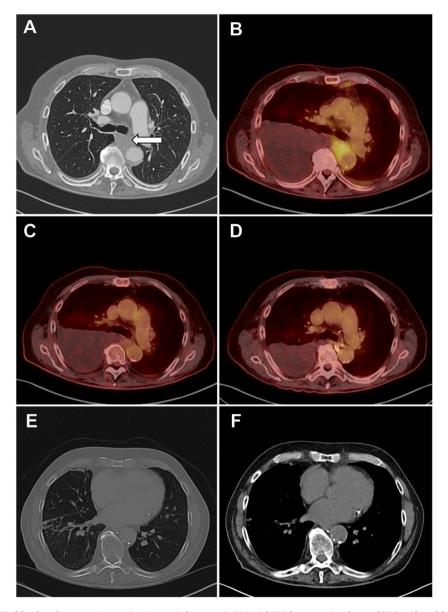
(A) Contrasted CT of the chest demonstrating a periaortic mass (white arrow). (B) Initial PET demonstrating abnormal FDG-avidity of the soft mass encasing the descending thoracic aorta. (C) PET mid-chemoimmunotherapy demonstrating interval decrease in size and FDG uptake of the soft tissue in the posterior mediastinum. (D) PET post-chemoimmunotherapy demonstrating no evidence of disease or FDG-avidity of the soft mass encasing the descending thoracic aorta. CT of the chest post pleurectomy demonstrating resolved pleural effusion; (E) lung enhanced view and (F) mediastinal view.
